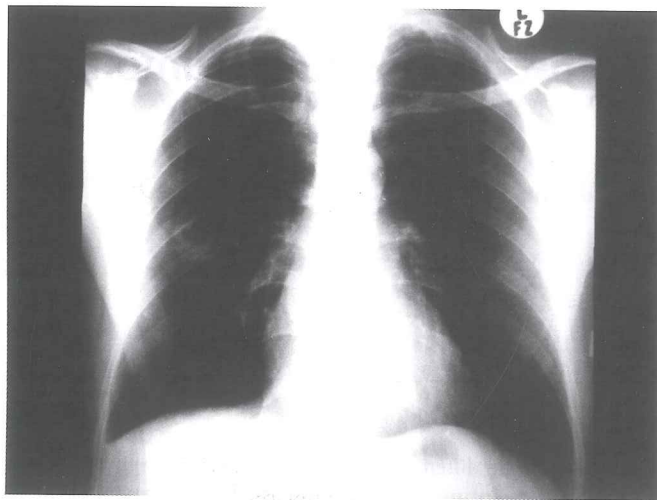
Chest radiograph on admission showing a cavity in the right middle zone.
